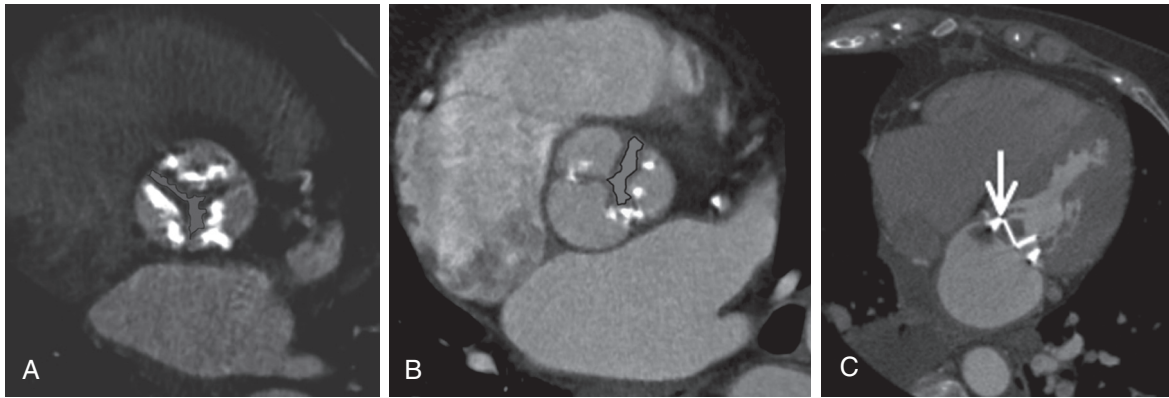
Valvular heart disease on cardiac CT. A, Aortic stenosis is characterized by restricted motion of calcified valve leaflets in systole. Planimetry of the aortic valve area showed severe aortic stenosis, with an area of 1 cm^2 . B, Malcoaptation of the aortic valve leaflets in diastole with an area of 0.8 cm^2 , consistent with severe aortic regurgitation. C, Bileaflet prosthetic mitral valve with a stuck leaflet secondary to subacute valve thrombosis (arrow).
